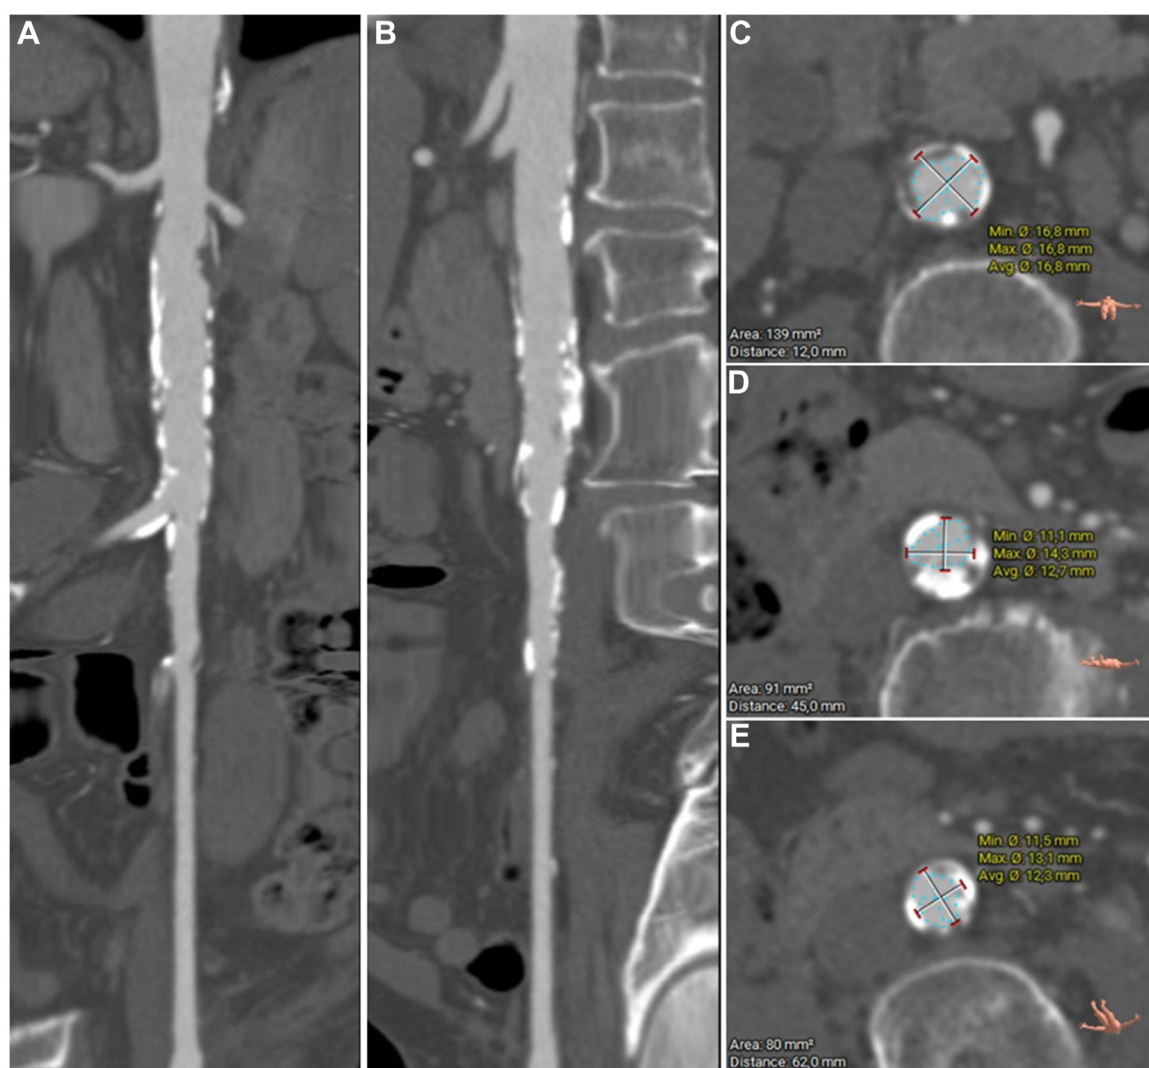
Centerline reconstruction of 1-month postoperative computed tomography angiography (CTA) reveals the regular patency of the infrarenal aorta in both the anteroposterior (A) and lateral views (B). Transverse sections provide detailed visualization of the aortic lumen before (C) and at the site of stenosis (D), followed by the poststenotic segment (E).
